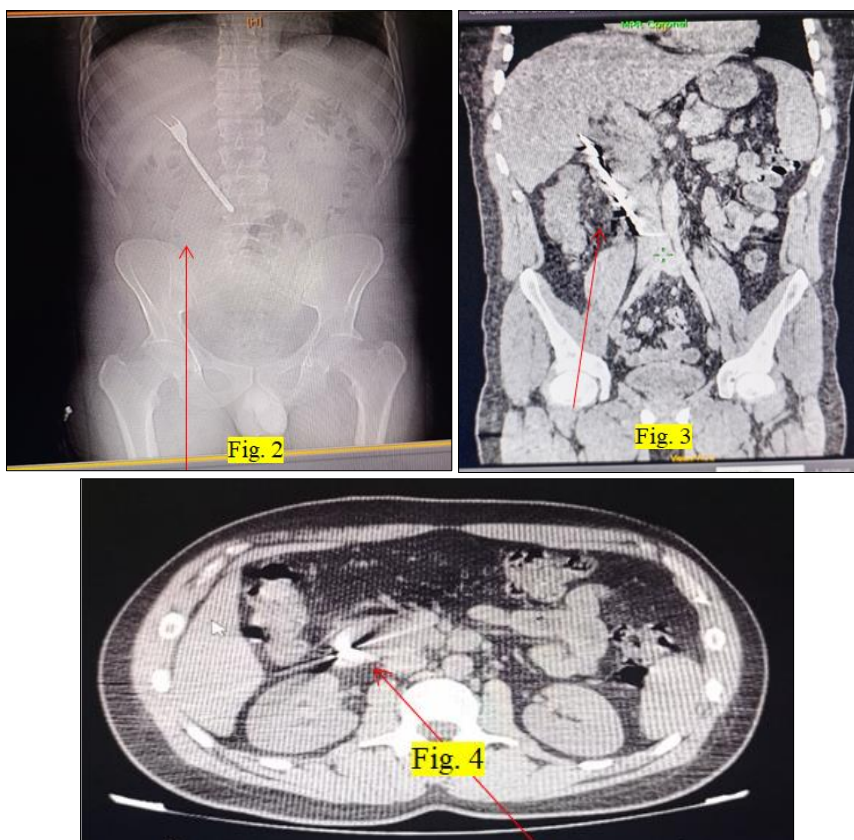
Fig. 3, Fig. 4: CT scan images on different sections showing the fork (Fig. 2) and a linear structure (Fig. 3 and Fig. 4) at the D2 and D3 levels, generating a metallic artifact, obstructing wall exploration, and measuring 9x136 mm.
